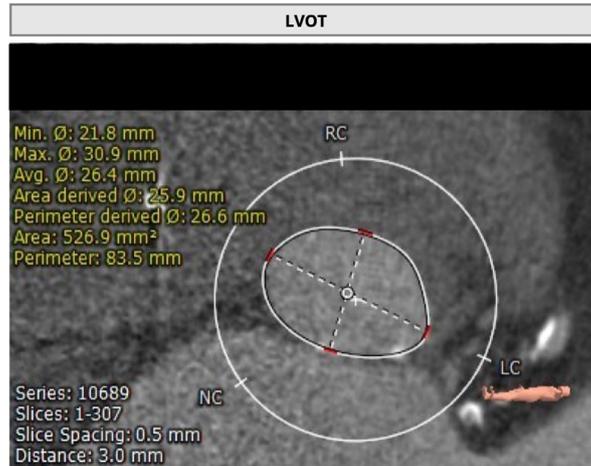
Multidetector computed tomographic angiography, zoomed short-axis display of the aortic valve and LVOT, demonstrating pre-TAVI measurements.
